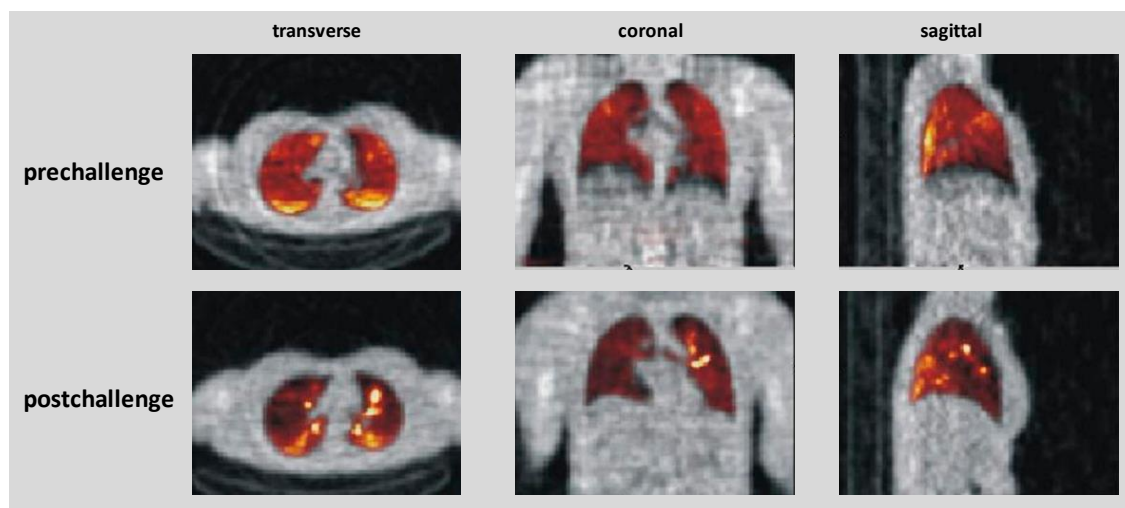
Images from a PET scan obtained following inhalation of [^{18}F]FDG aerosol in one subject with asthma and immediately after a methacholine challenge. The baseline scan is reasonably uniform with ventilation posterior and basal as seen in the one slice in the transaxial plane. On the repeat scan, hot spots are evident throughout the lung as seen on these single slices from the transaxial, coronal, and sagittal planes. Adapted from (Dolovich, 2009).
